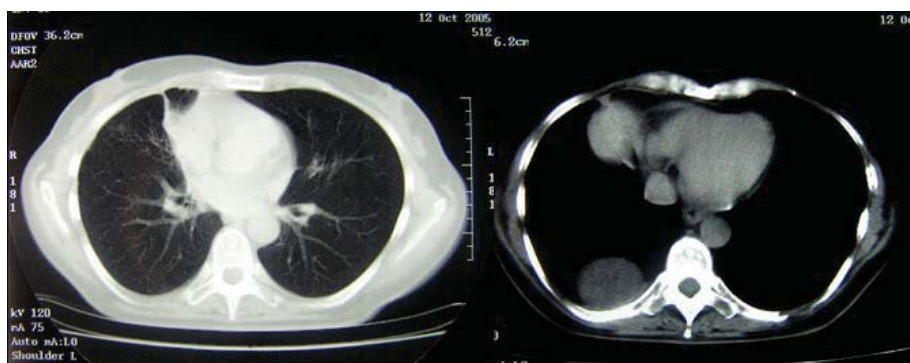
Computed tomography of the chest in the presented patient 5 months after the antibiotic therapy completion.
